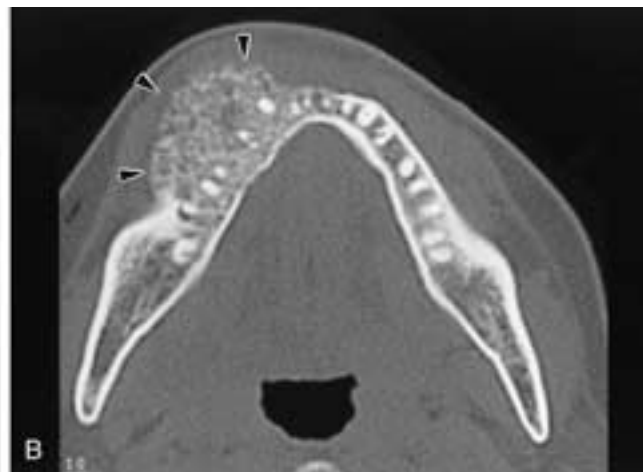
Desmoplastic variant of ameloblastoma in the mandible. A, Panoramic radiograph shows a diffuse, mixed radiolucent-radiopaque lesion in the mandible (*arrowheads*). B, Axial CT shows a definite buccal expansile radiolucent-radiopaque lesion (*arrowheads*). (Courtesy of Dr. T. Kurabayashi, Dept. of Dental Radiology, Tokyo Medical and Dental University, Tokyo.)
